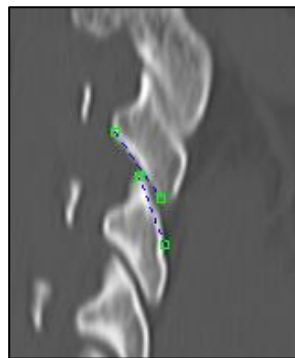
Para-sagittal CT image used to calculate facet apposition.
